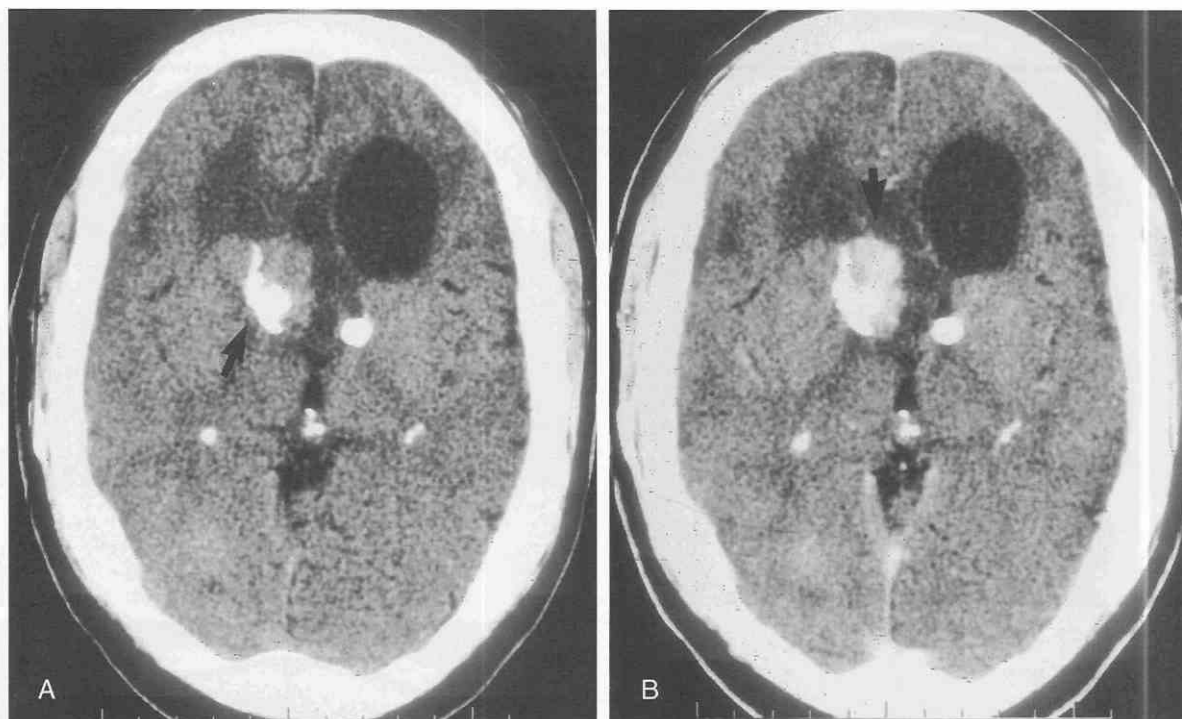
Subependymal giant cell astrocytoma in a patient with tuberous sclerosis. Axial CT images prior to (A) and following (B) intravenous administration of iodinated contrast medium. A partially calcified (arrow in A) multilobulated mass arising on the medial surface of the head of the right caudate nucleus fills and obscures the frontal horn of the right lateral ventricle. On the left, a calcified tuber (not neoplastic) obstructs the foramen of Monro; the dilated left frontal horn is compressed and displaced by a cyst, which is likely secondary to previous ventriculostomy complication. The noncalcified portion of the right frontal intraventricular tumor demonstrates homogeneous contrast enhancement (arrow in B).
